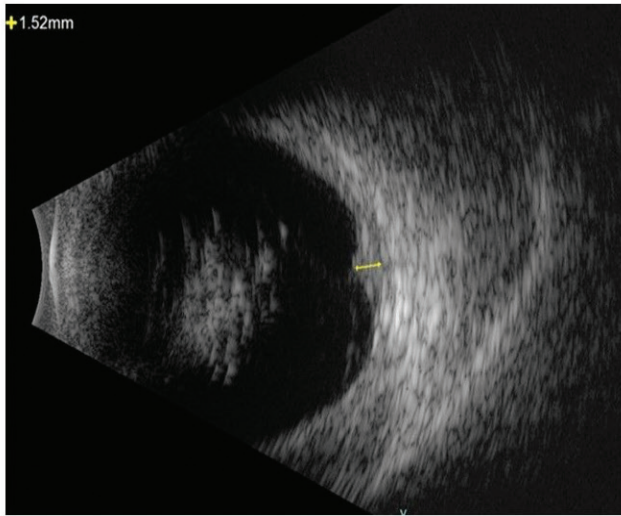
Ocular ultrasound (B-mode) of left eye at presentation revealed the presence of dense vitreous opacities and a homogenous hyperechogenic retinal lesion with a thickness of 1.5 mm (yellow mark)
